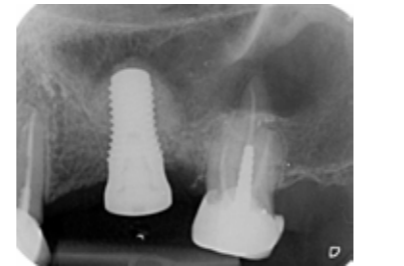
X-ray image immediately after surgery.
